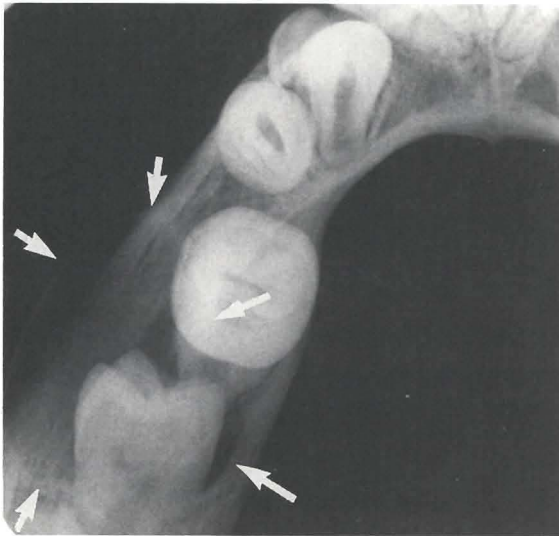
Occlusal radiograph (7/90) showing: margins of the inflamed epithelial cyst, labial and distal to teeth numbers 18 and 19 (arrows).
